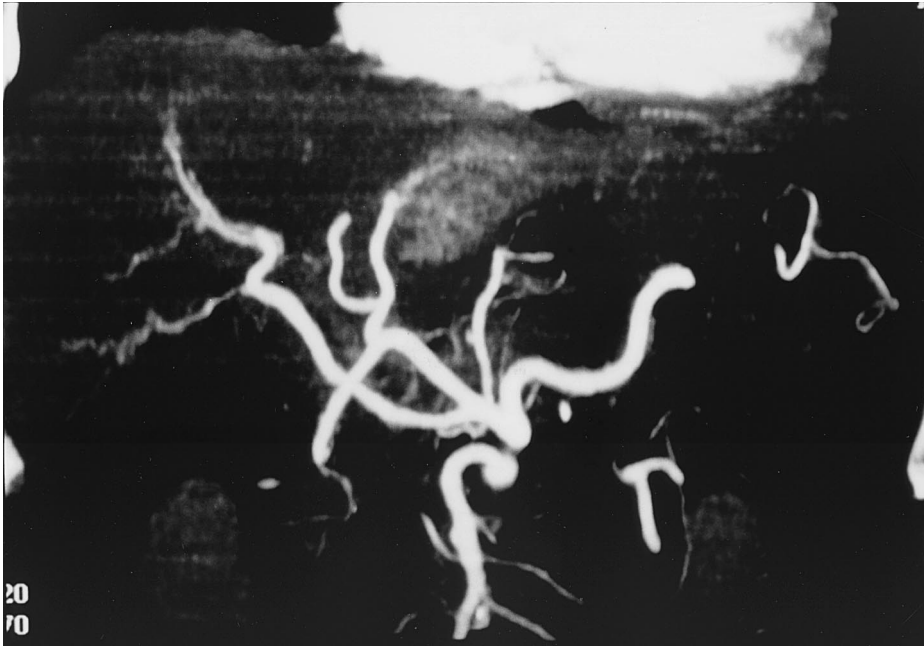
CT arteriography of the celiac arterial branches of normal variant, reconstructed from early arterial phase images. Note the major arterial trunk and its small branches, the right hepatic artery arising from the celiac axis, middle and left hepatic arteries, left gastric artery, and gastroduodenal artery.
